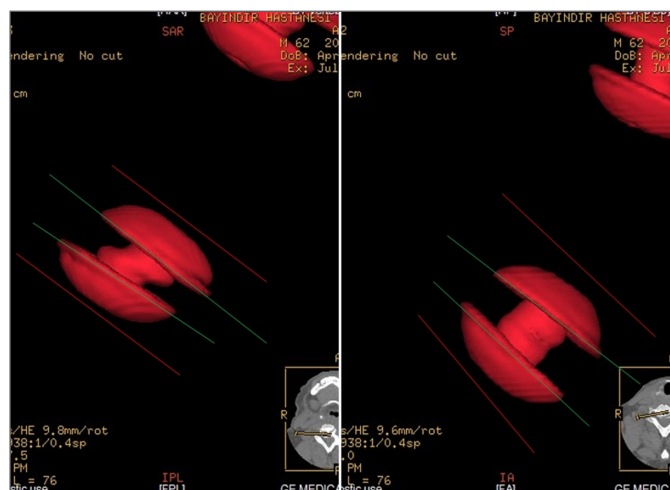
The 6° micromotion at the bone–implant interface was evaluated simultaneously on the same flexion and extension CT sections at the same level by digitally subtracting the prosthesis ROM from the vertebral ROM.
